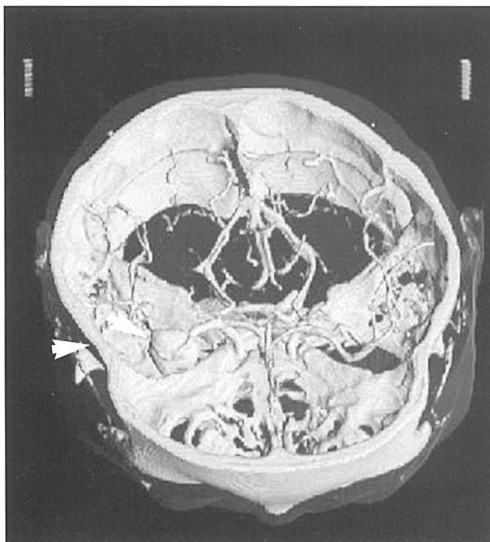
CT angiogram, volume rendering technique, anterosuperior view, demonstrates a large right middle cerebral artery aneurysm. The relationship of this aneurysm to the inner table of the skull is well shown (arrows).
